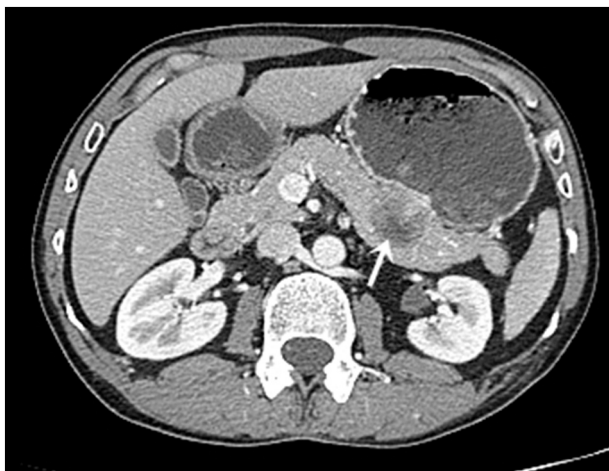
Abdominal enhanced computed tomography showing a solido-cystic mass located in the pancreatic body-tail (arrow).
